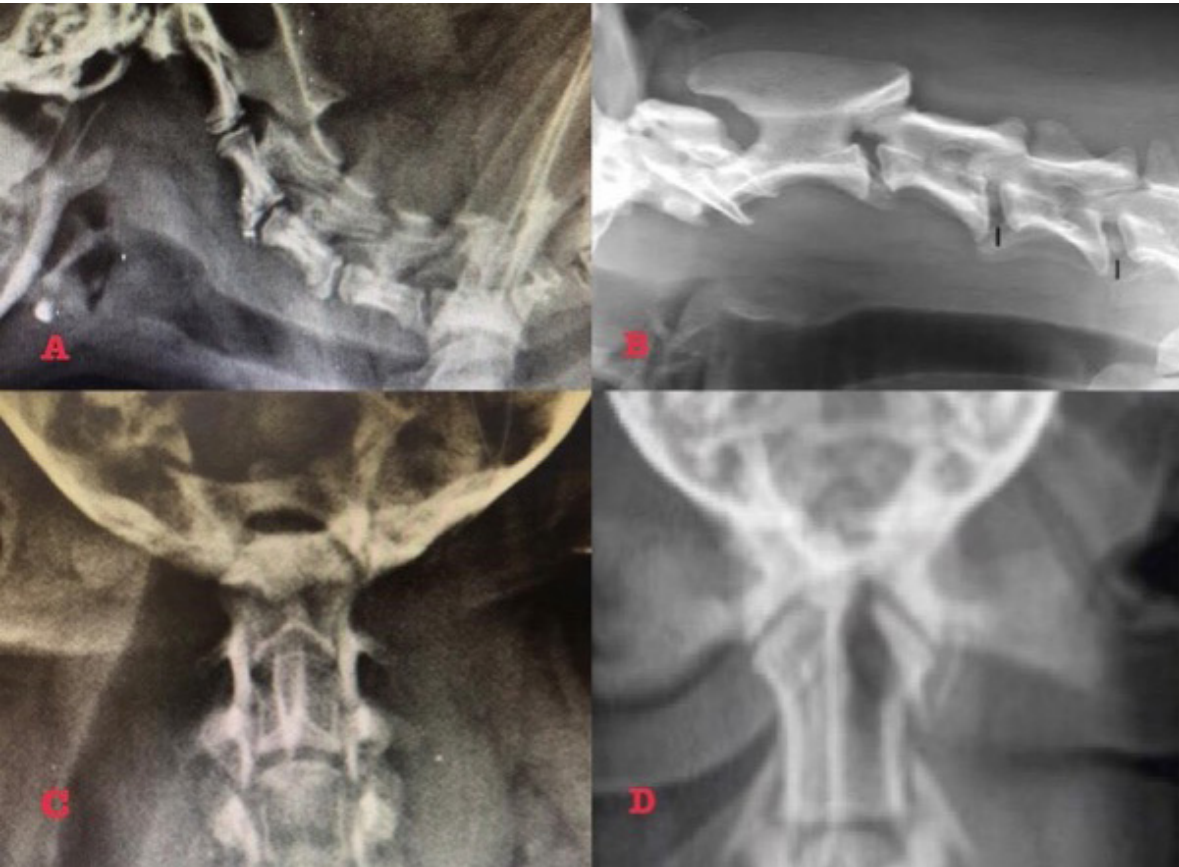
Radiographic images of cervical spine (C1-C7): A: dorsal subluxation of the axis and excessive gap between spinous process of the atlas and axis, B: normal cervical vertebrae, C: no dens were found in the image, D: normal cervical vertebrae
